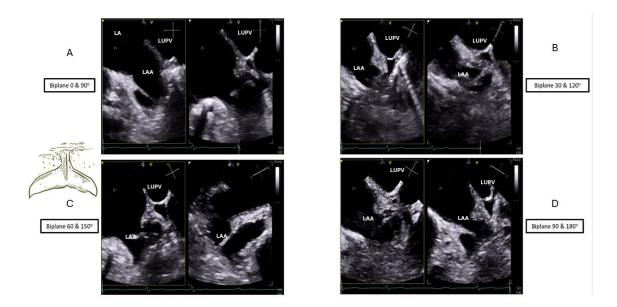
2D Transesophageal multiplane images at different angles. Figure 1C and 1D demonstrating the whale-tail appendage morphology.
